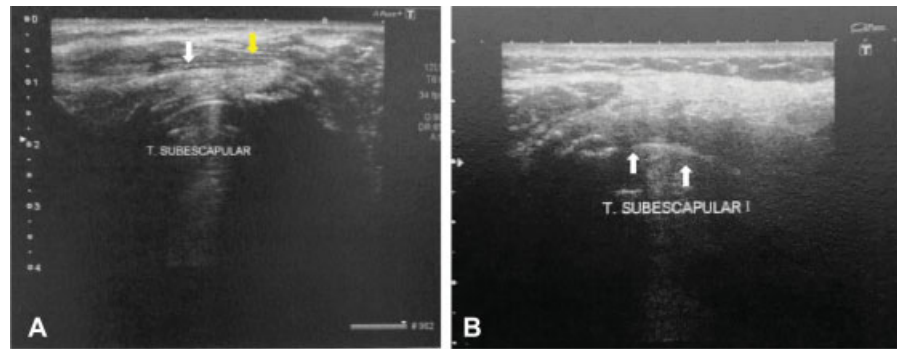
Ultrasound examination for subscapularis muscle tendon integrity evaluation. (A) Preserved thickness, regular contours, and usual hypoechogenic appearance of the subscapular tendon; (B) tendon not individualized, with an anechoic area in its topography.
